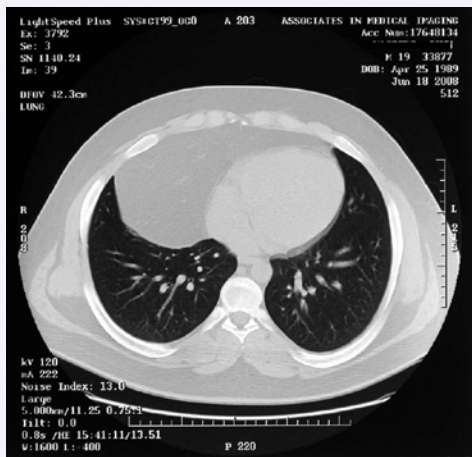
CT of chest showing omentum in the Morgagni hernia sac.
